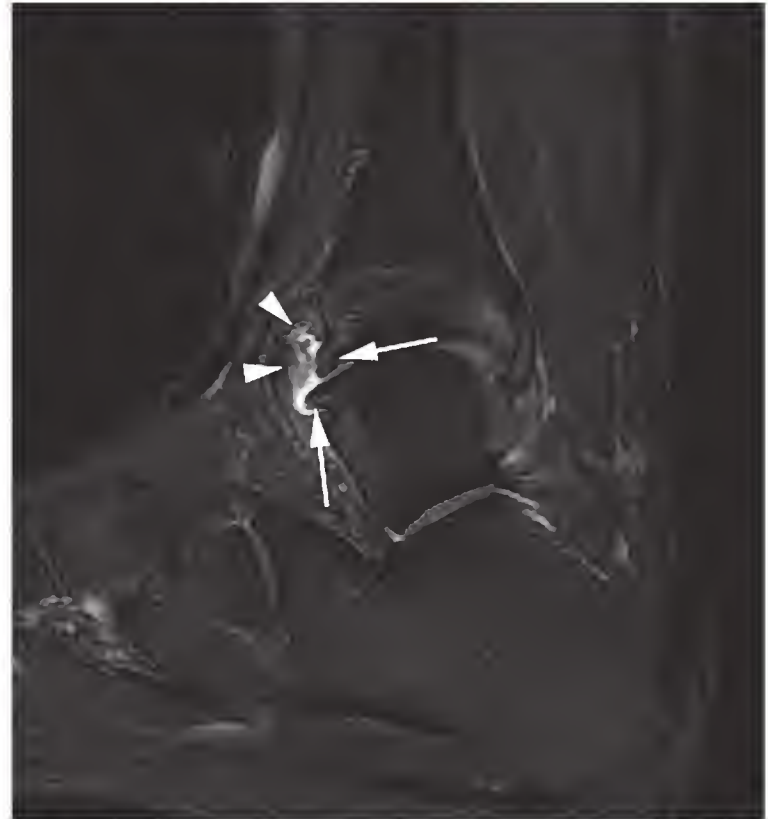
Sagittal T2-weighted magnetic resonance image showing anterior tibiotalar spurs (white arrows) and synovitis (arrowheads). (From Conaghan PG, O'Connor P, Isenberg D, editors. *Musculoskeletal imaging. Oxford specialist handbooks in radiology*. Oxford: Oxford University Press; 2010. With permission.)
